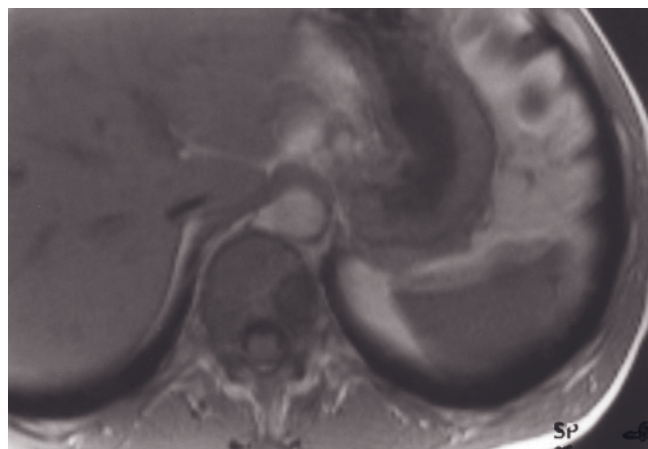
Hemangiomas. T1-weighted SGE (a), T2-weighted fat-suppressed spin-echo (b), and 45-s (c) and 10-min (d) postgadolinium SGE images. Two small, <1.5 cm, hemangiomas are present that are minimally hypointense on T1-weighted images (a) and moderately hyperintense on T2-weighted images (arrows, b). Peripheral nodules are present on early postgadolinium images (c), and enhancement progresses to uniform high signal intensity by 10 min (d). T1-weighted SGE (e), T2 fat-suppressed spin-echo (f), immediate postgadolinium T1 SGE (g), and 90-s postgadolinium T1-fat-suppressed SGE (h) images in a second patient.
